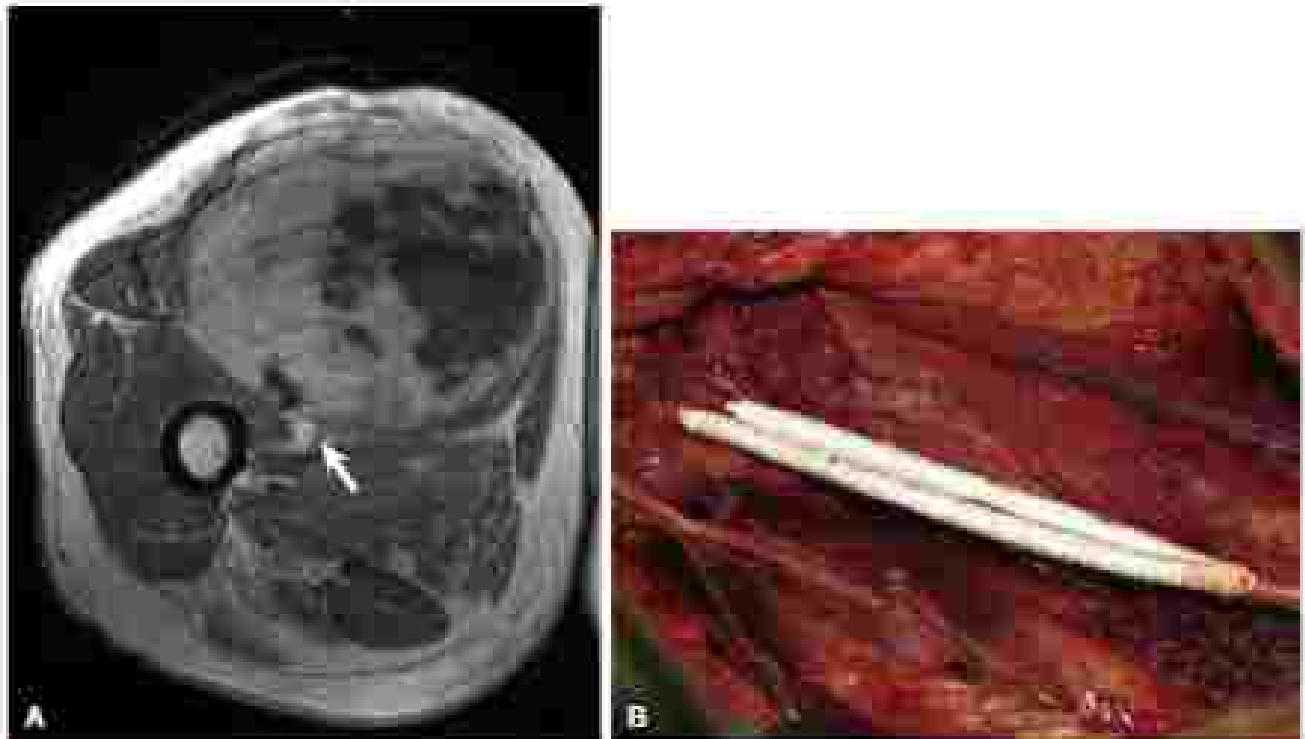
(A) Axial MRI image of a myxopapillary ependymoma of the thigh involving the femoral nerve. (B) Intraoperative view of the surgical field with vascular replacement of both artery and vein.
